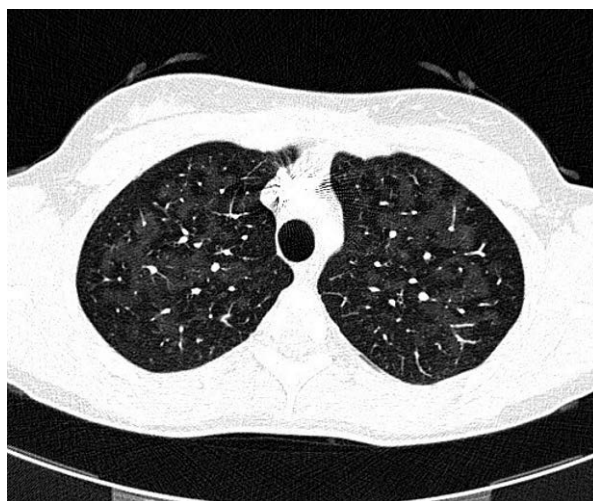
Focal ground glass opacities in high resolution computed tomography of the lung of 19-years old female patient with idiopathic pulmonary arterial hypertension
